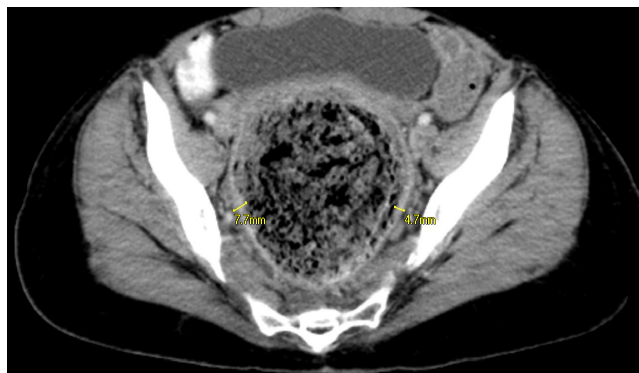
CT scan demonstrated thickening of colonic wall with large volume of faeces
